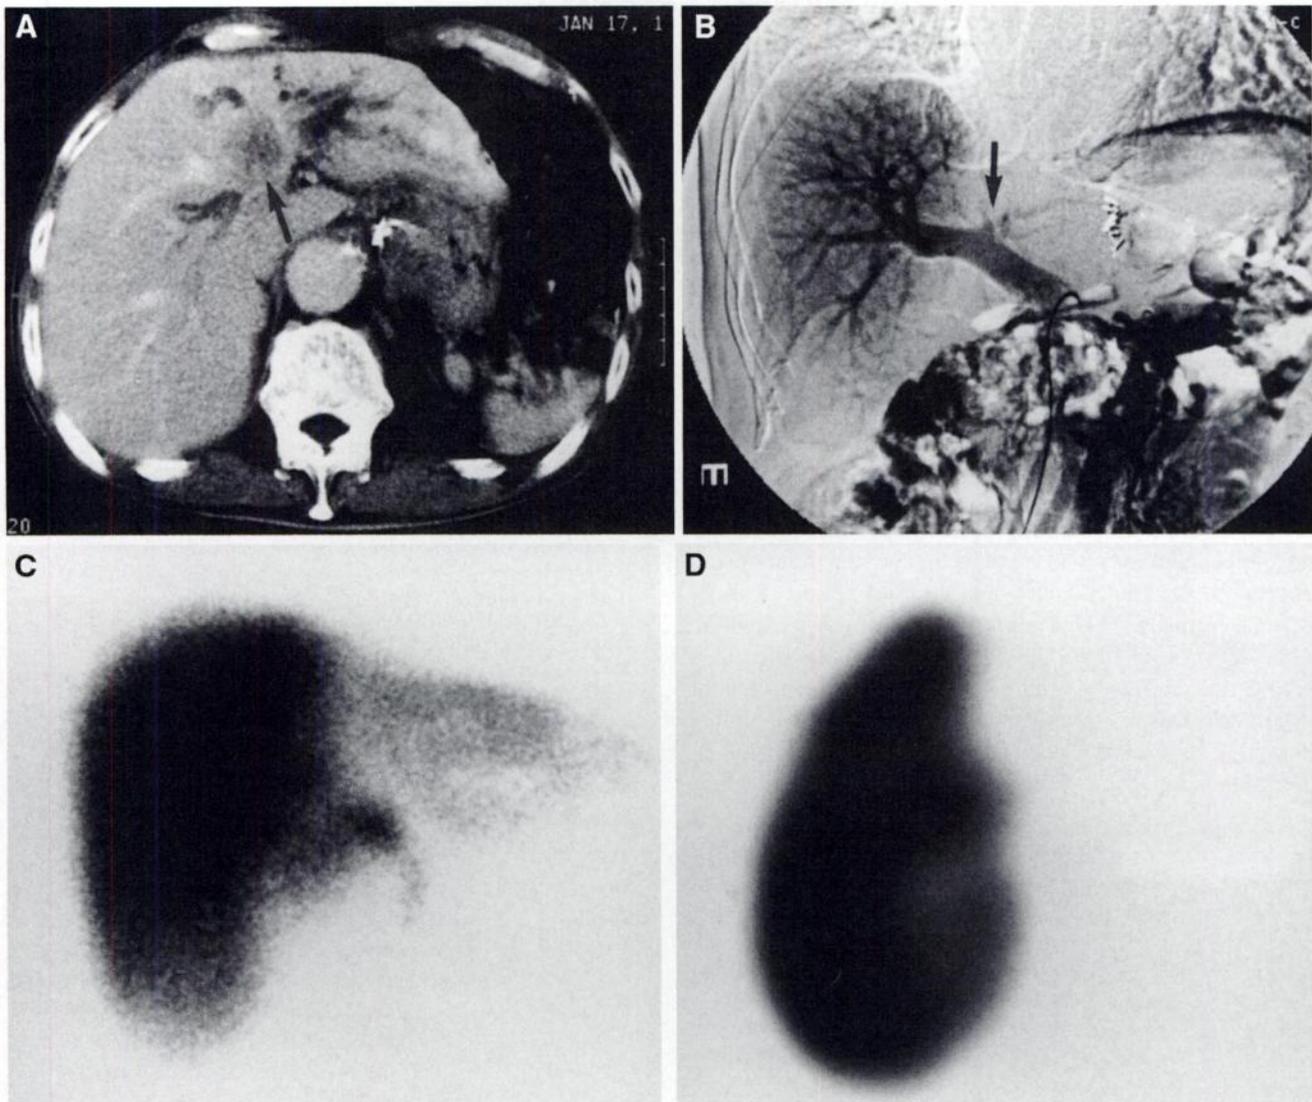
78-y-old man with hilar cholangiocarcinoma. (A) Enhanced CT scan shows hilar mass (arrow) and dilated right and left hepatic ducts. Dilatation is asymmetric and predominant in left lobe. (B) Portogram via superior mesenteric artery shows stenosis of left portal vein (arrow) and decreased portal perfusion in left lobe. Anterior (C) and transaxial (D) SPECT images show decrease in ^{99m}Tc -GSA accumulation in left lobe. Cause of functional laterality is considered to be decreased portal perfusion in left lobe or intrahepatic biliary stasis predominant in left lobe or both.
